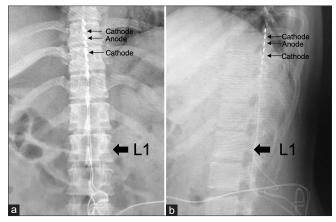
Plain X-ray ((a) anteroposterior view; (b) lateral view) of postoperative lumbar X-ray.
